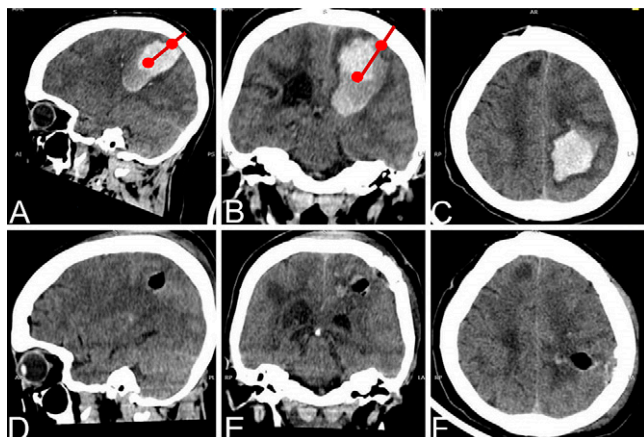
Brain computed tomography without contrast. Preoperative sagittal (A), coronal (B), and axial (C) sections showing right frontoparietal intracerebral hematoma, in addition to planning using the two-point method. Postoperative sagittal (D), coronal (E), and axial (F) sections showing clean surgical bed without residual bleeding.
